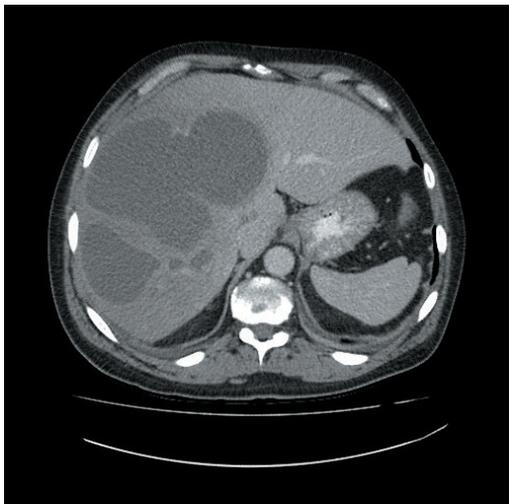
CT scan of case 1 showing a huge multilocular abscess
